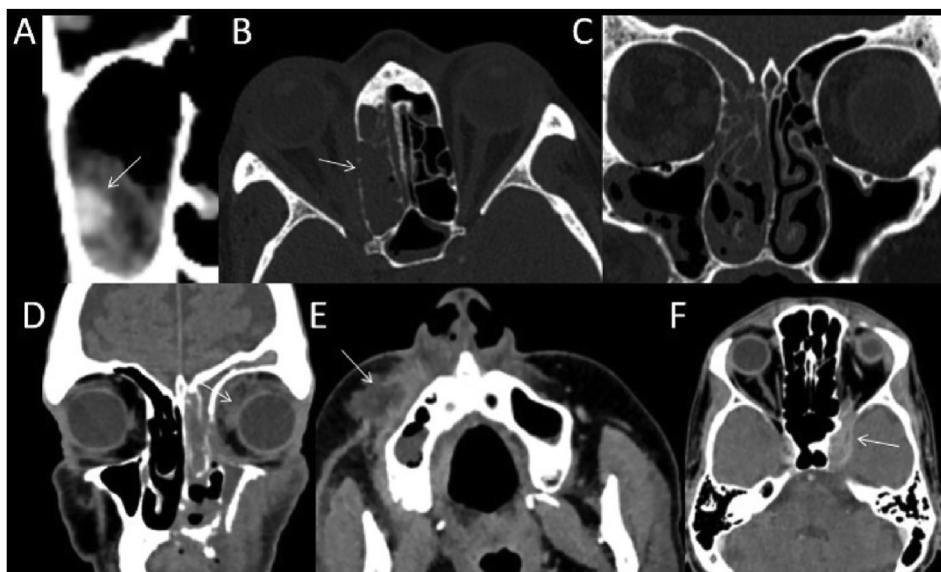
Varied findings of Mucormycosis on computed tomography in COVID-19 patients. (A) Coronal CT image shows hyperdense areas (arrow) within the right maxillary sinus contents, finding strongly suggestive of fungal aetiology. (B) Axial CT image shows break in the lamina papyracea (arrow). (C) Coronal CT image shows involvement of right maxillary, bilateral ethmoid sinuses and the right orbit with break in the lateral lamella (right) (D) Coronal CECT image shows involvement of left maxillary and ethmoid sinuses with a collection in the left orbit. (E) Axial CECT image shows extension of infection to involve right buccal space with resultant abscess. (F) Axial CECT image shows involvement of left cavernous sinus.
